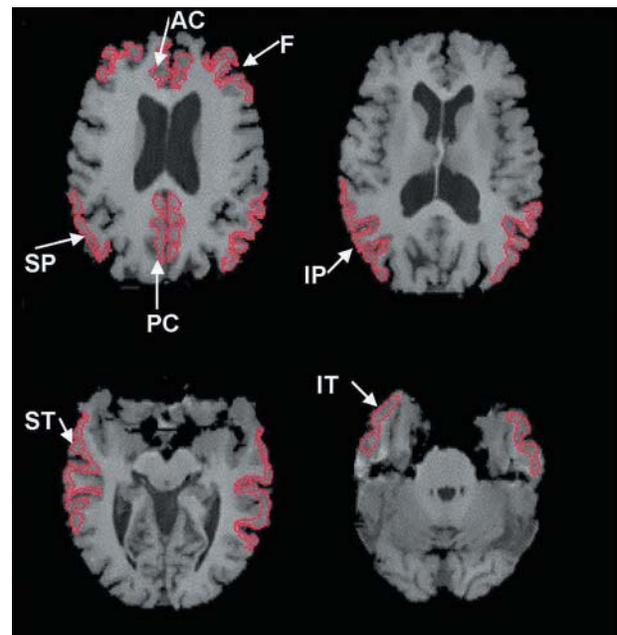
Examples of regions of interest are shown on spoiled gradient recall magnetic resonance images. AC, anterior cingulate; F, dorsolateral prefrontal cortex; IT inferior lateral temporal; IP, inferior lateral parietal; SP, superior lateral parietal; ST, superior lateral temporal.
